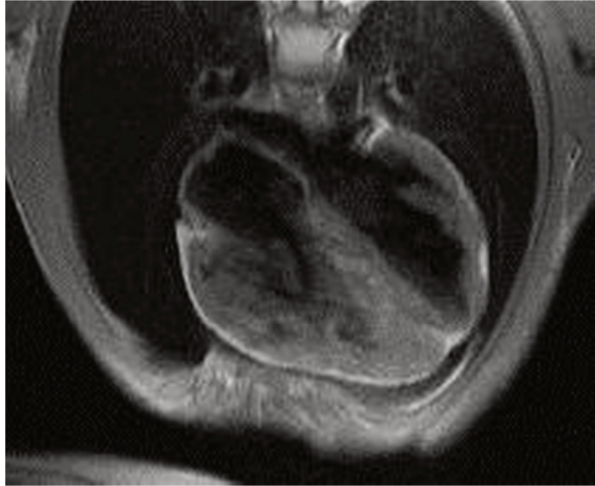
ACM fatty variant on cardiac MRI. Note the typical biventricular fatty replacement (*bright white* signal intensity) of the entire RV wall and of the LV lateral wall. From Perazzolo Marra et al., 2015.
